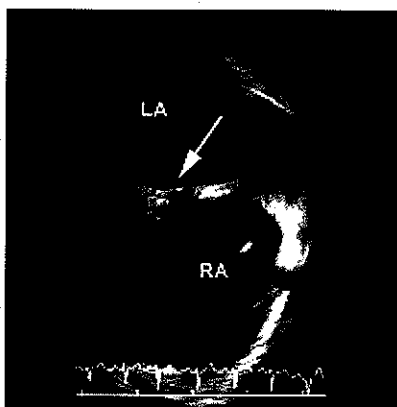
Small fossa ovalis detected by intracardiac echocardiography. In this patient the size of the fossa ovalis was 4.8 mm.
